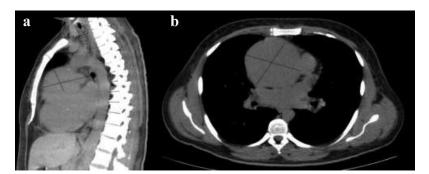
Sagittal (a) and axial (b) views of a thoracic computed tomography scan depicting a giant aortic aneurysm in a patient with PAMM.
